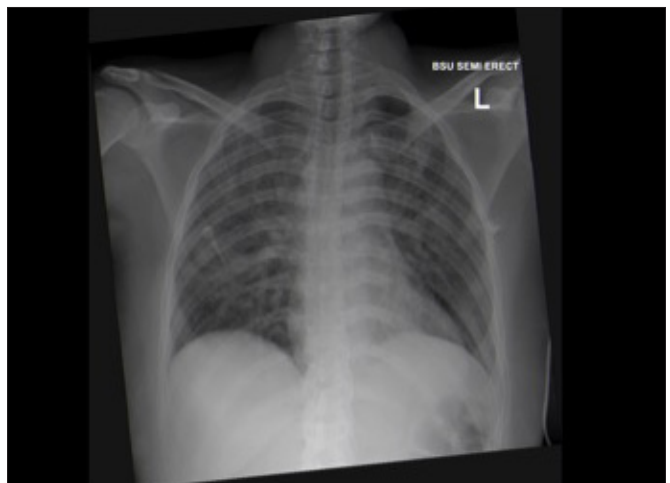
Chest X-ray showing bilateral shadowing in case 1.
